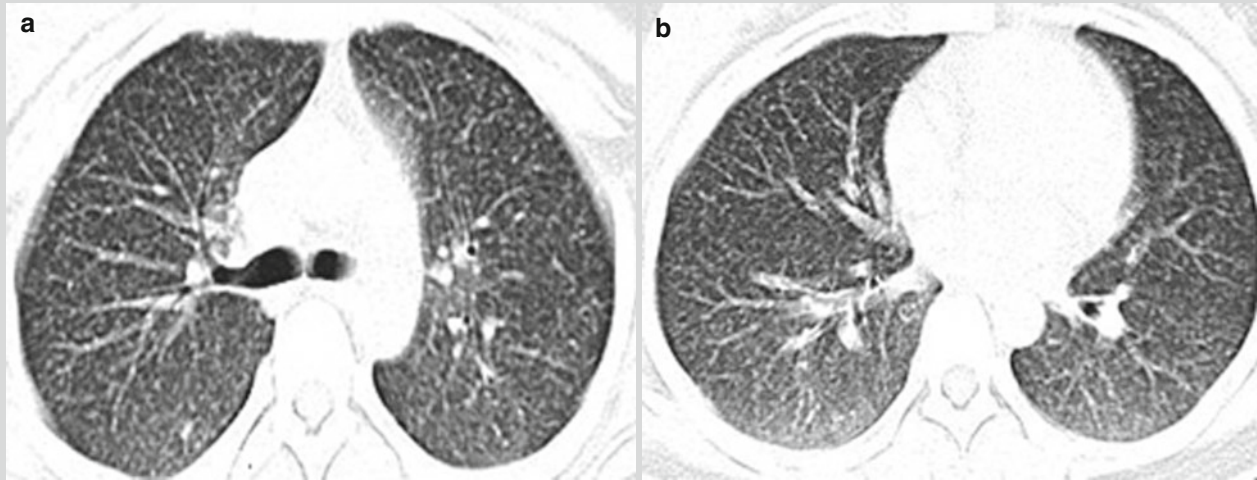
Acute miliary pulmonary TB. (a, b) CT scanning demonstrates diffuse miliary nodular shadows at both lungs with even size, even density, and even distribution
